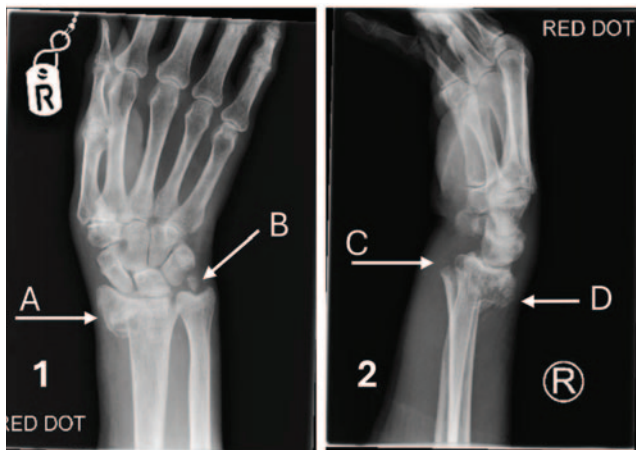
This is a Postero-Anterior (PA) radiograph of a right wrist. It shows an extra-articular distal radius fracture (marked A) with shortening and loss of radial inclination/angulation (i.e. the hand doesn't align with the forearm). There is also a fracture at the base of the ulna styloid (marked B) which is displaced.
